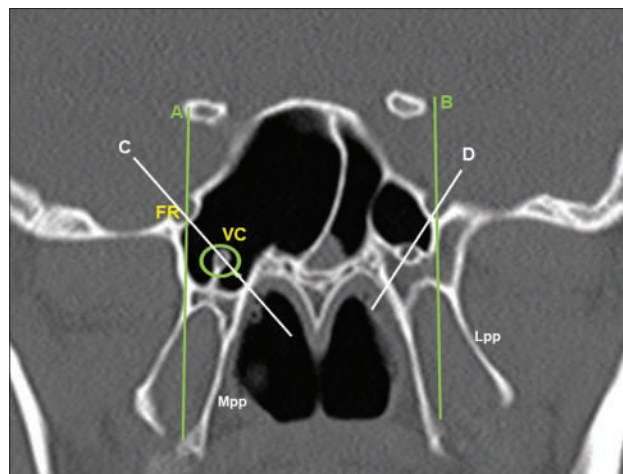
A coronal CT image showing the evaluation of FR, VC position, and SS pneumatization. Mpp: medial pterygoid plate, Lpp: Lateral pterygoid plate. CT: Computed tomography, FR: Foramen rotundum, VC: Vidian canal, SS: Sphenoid sinus
